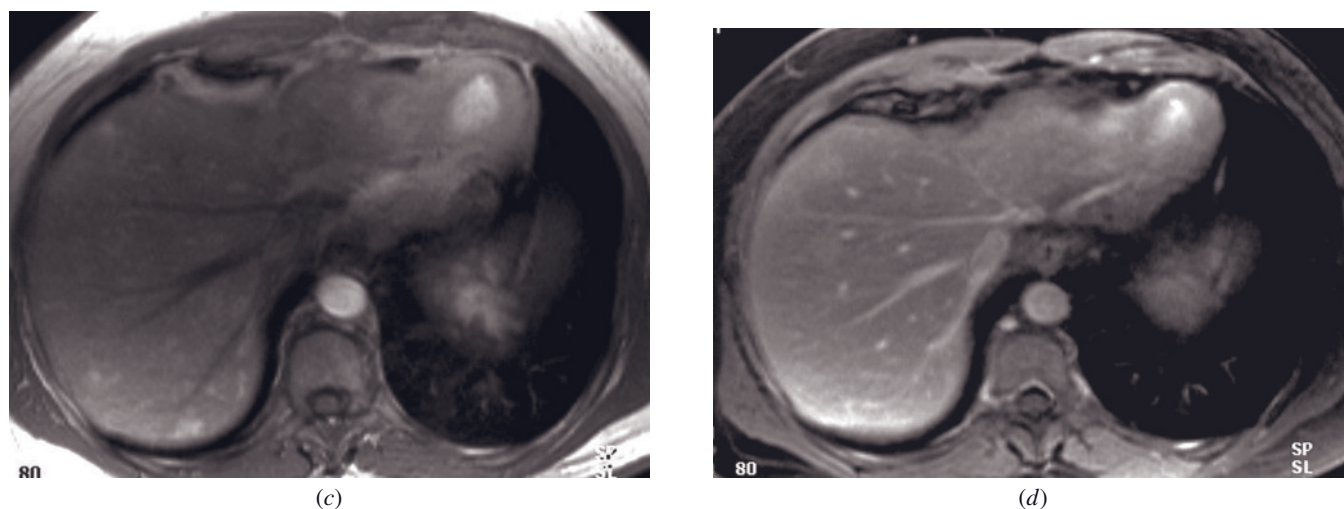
(Continued) isointensity on T2-weighted (*a*) and T1-weighted (*b*) images and intense enhancement on early-phase images (*c*) that fade to background parenchyma on late-phase images (*d*).
